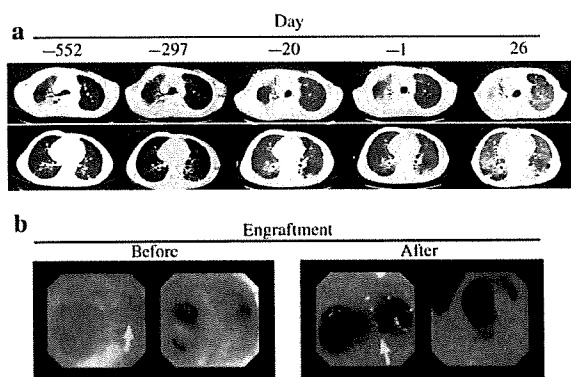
Chest computed tomography (CT) changes over time and bronchoscopy findings. (a) High-density areas were found all over the lungs more than a year before BMT. A cavity was also identified in the right upper lobe. The lungs appeared to worsen with time; however, a day before the transplantation, a temporary improvement was observed. On day 26, ground-glass opacity was observed in both lungs covering each lung. (b) A small amount of bronchial haemorrhage was observed before engraftment. Although bleeding from the right bronchial tube was also identified, this haemorrhage was arrested within a few days (left panel). Bronchial haemorrhage started again after engraftment. At this time, a blood clot (indicated by arrow) was deposited in the bifurcation of the trachea, and active bleeding was identified in the right S6 area (right panel).
